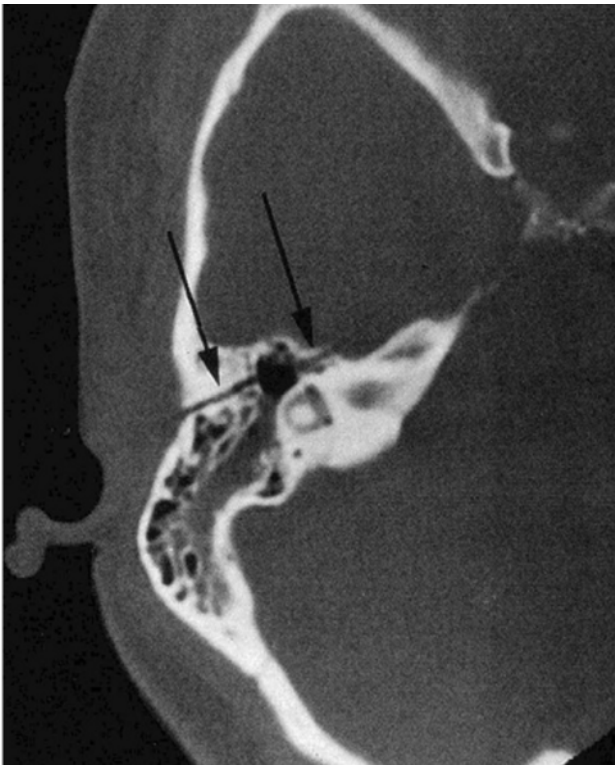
(a): CT scan showing longitudinal temporal bone fracture
